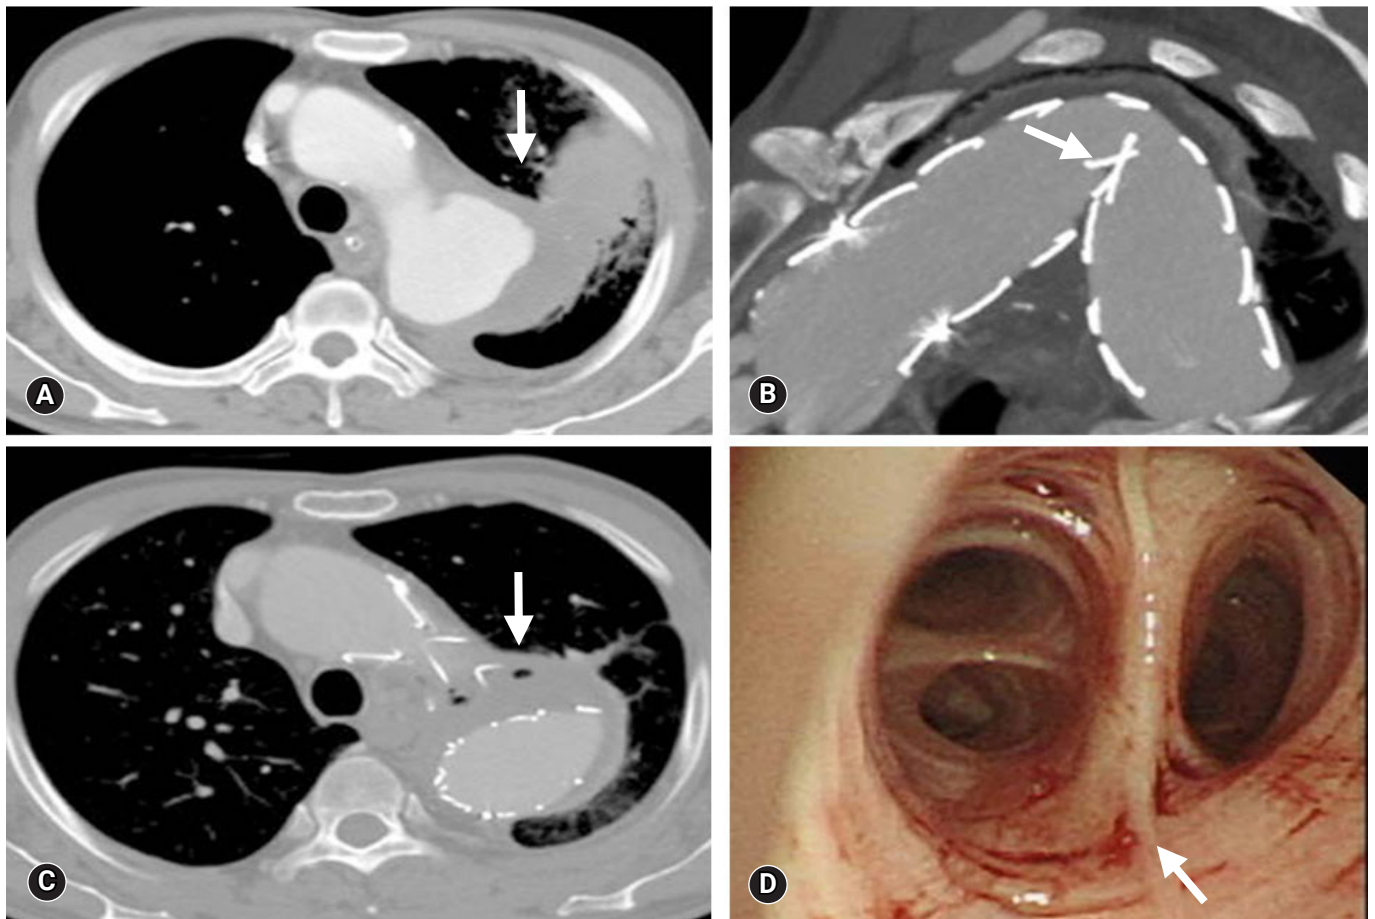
Chest computed tomography (CT) findings of case 2. (A) Initial chest CT indicates a pseudoaneurysm with a suspicious aortobronchial fistula lesion (arrow). (B) A follow-up chest CT reveals kinking stenosis of the aortic isthmus stent-graft (arrow). (C) Chest CT on admission reveals air entrapment within the thrombosed aneurysm (arrow). (D) Bronchoscopy shows oozing at left upper lobe orifice (arrow).
